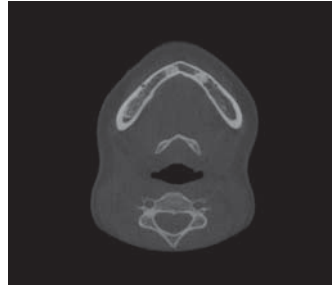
Axial image reconstructed from cone-beam CT data showing multiple enostosis/dense bone islands.
